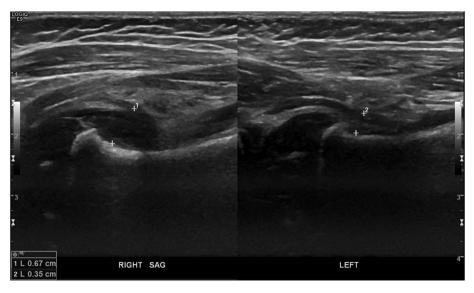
Ultrasonography examination of bilateral hip joints. There is a right joint discrepant effusion as compared to the normal left side, with surrounding hyperemia and internal turbid fluid.
